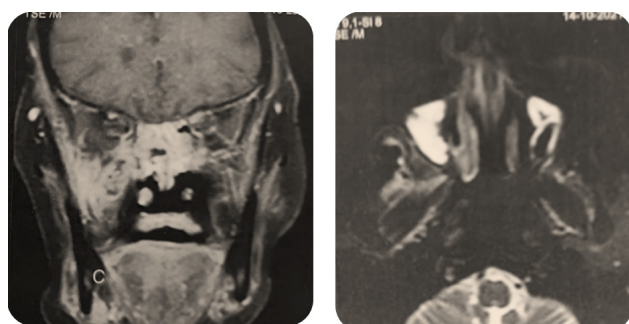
MRI scan a) T1+C shows hyperintense signals within RT PPF-ITF denoting inflammatory process b) T2 fat suppression shows hyperintense signal within infratemporal muscles and fat planes denoting inflammatory process
